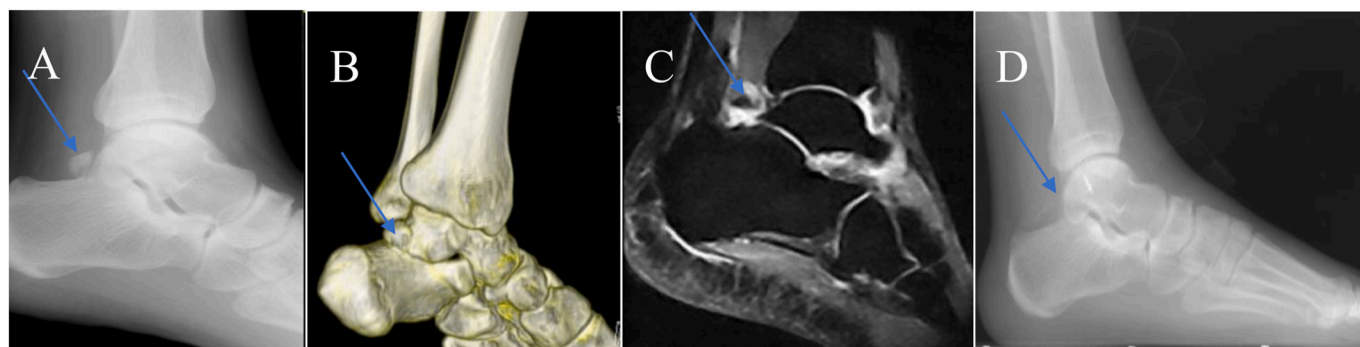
This was a typical case: A, B, C. Pre-operation, X-ray, CT, and MRI examination showed that the patient suffered posterior ankle impingement syndrome. D. Post-operative X-ray examination showed that all bony impingements were removed entirely.
